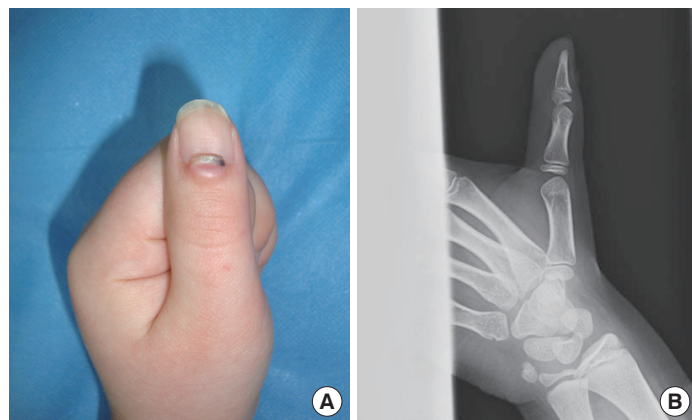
Preoperative findings of the case. (A) A solitary, localized, well-demarcated, 7 mm × 5 mm, whitish hyperkeratotic nail-like skin lesion on the center of the left thumb. (B) No underlying bone deformity is visible on plain radiography.
